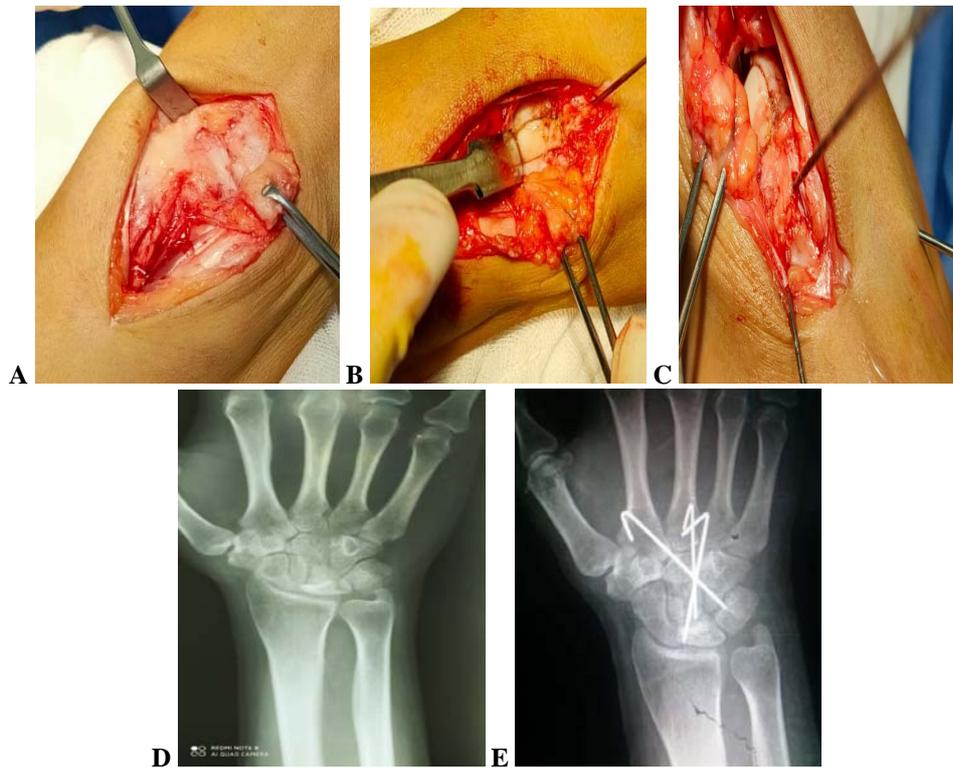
(A) Opening of the capsule. (B) Reverse L"-shaped osteotomy of the capitate. (C) Fixation of the mobile segment of capitate by k-wires. (D) Pre-operative x-ray of the patient with grade IIIA Kienbock disease. (E) Post-operative x-ray showing capitate shortening.
